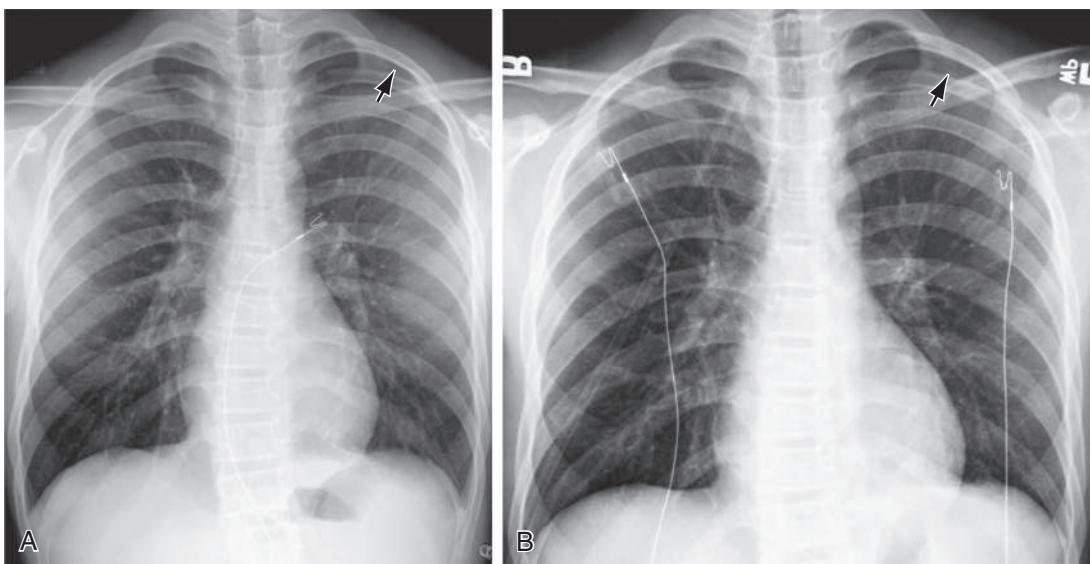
Utility of an expiratory film in detection of a small pneumothorax. A, Teenager with stab wound and subtle radiolucency in the left apical region (arrow) on inspiratory chest radiograph. The margin of the visceral pleura is very faintly visible. B, On an expiratory film, the pneumothorax (arrow) is more obvious as the right lung has deflated and become more opaque, providing better contrast with the air in the pleural space.
